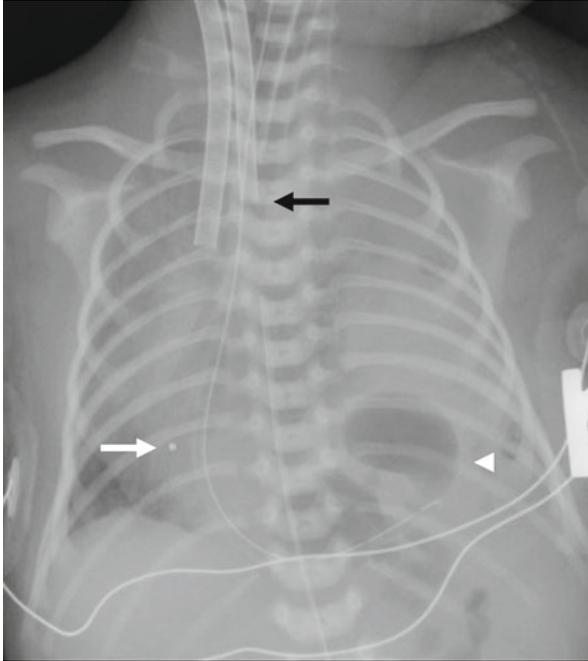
ECMO cannulas. Chest radiograph in a neonate with left congenital diaphragmatic hernia on ECMO. The venous cannula tip (*white arrow*) is located at the expected location of the right atrium. The arterial cannula tip (*black arrow*) is located at the innominate artery/aorta junction. Note the tip of the NG tube (*arrowhead*) in the herniated stomach
